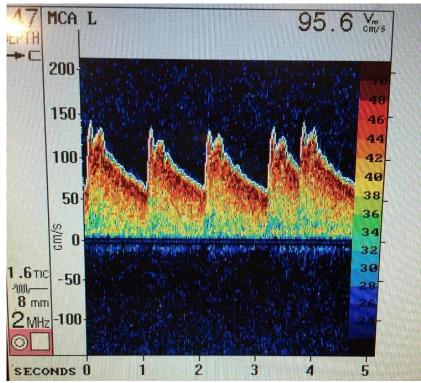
Transcranial Doppler ultrasound waveforms indicative of strong middle cerebral artery signal. Values presented as raw sample of one participant.
